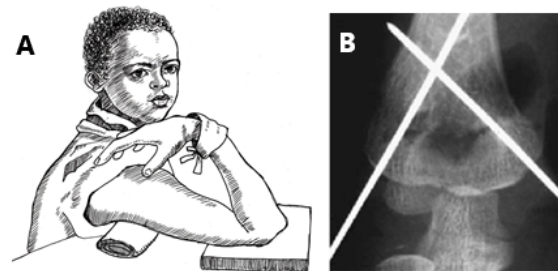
CHECKING SUPRACONDYLAR FRACTURE REDUCTION. A, positioning the arm and the film to take the radiograph. *Don't let an assistant remove the collar & cuff to X-ray the arm. Make sure it is held in place without safety pins!* B, the post reduction radiograph. B, take a lateral and an AP view through the point of the elbow as shown. *Note the K-wires in place.*
